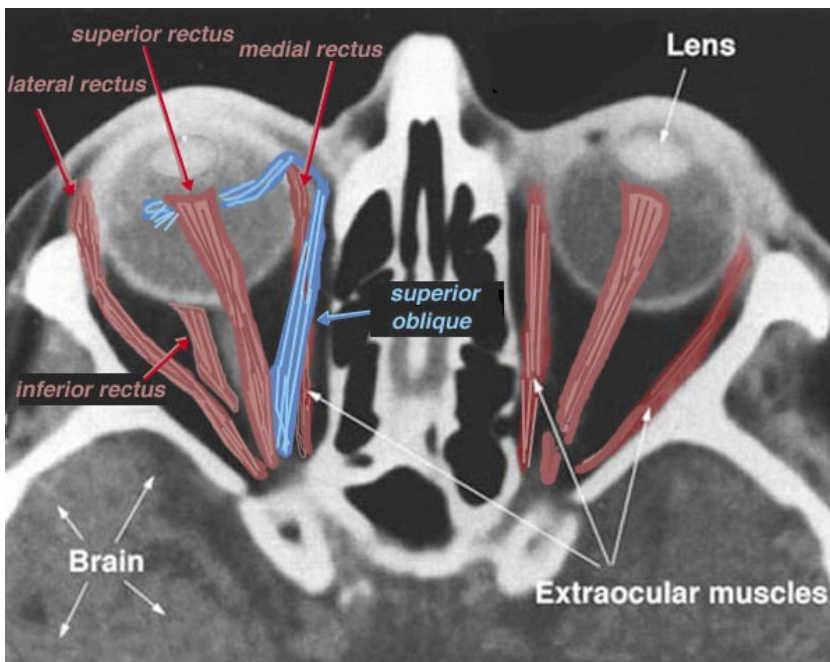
Anatomy of extraocular muscle on CT (Kolb, 2015)
